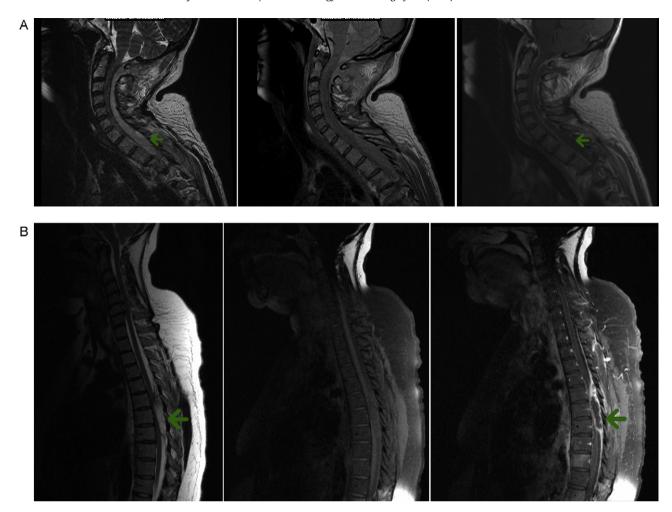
Magnetic resonance imaging of cervical and thoracic spine. (A) From left to right: sagittal T2, T1, and contrast enhanced T1 weighted MRI of patient 1 cervical and thoracic spine. Extensive epidural abscess (arrows) from C1/2 to thoracic level unseen on imaging. (B) From left to right: sagittal T2, T1, and contrast enhanced T1 weighted MRI of patient 2 thoracic spine. Arrow indicates level of epidural abscess.
